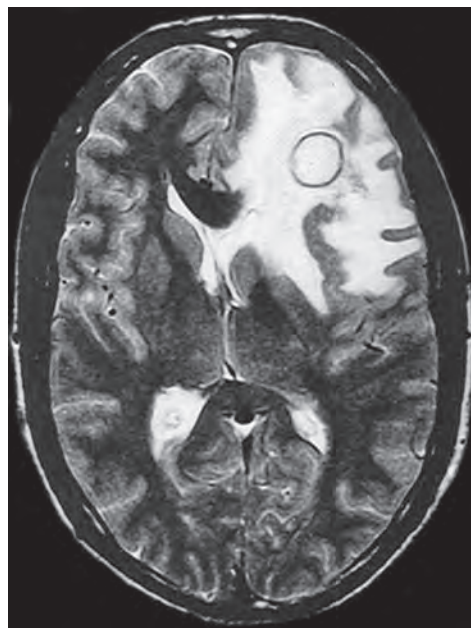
T2-weighted magnetic resonance of the same patient showing hypointense rim at the margin of the abscess
